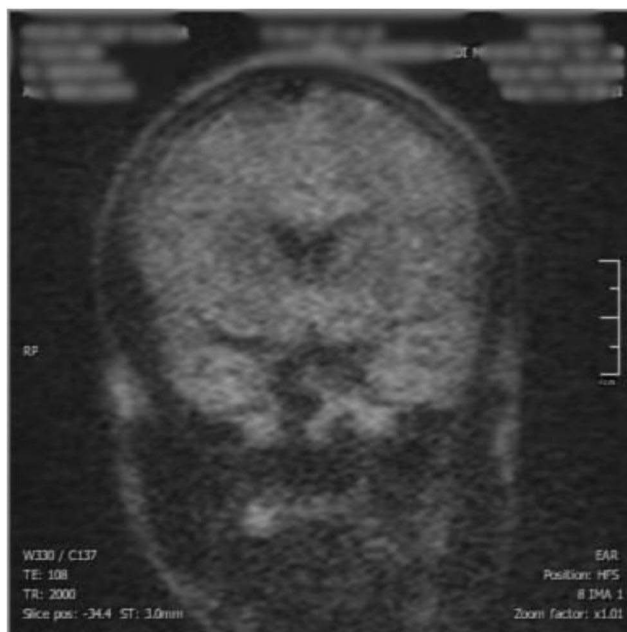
Coronal diffusion-weighted image (DWI) confirming the diagnosis. The lesion demonstrates marked hyperintensity (high signal), indicating restricted diffusion. This finding is highly characteristic of cholesteatoma and is crucial for differentiating it from other inflammatory conditions.
